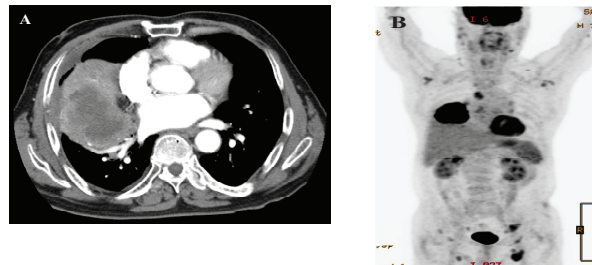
CT chest scan (A) and whole body FDG PET scan (B) of the patient. About 9.5 cm sized huge lung mass with central necrosis was detected in right lower lobe and the mass had a hypermetabolic walled cavity. Multiple metastatic lesions were also showed in both of neck, axillae, inguinal regions and mediastinum including right hilum.
